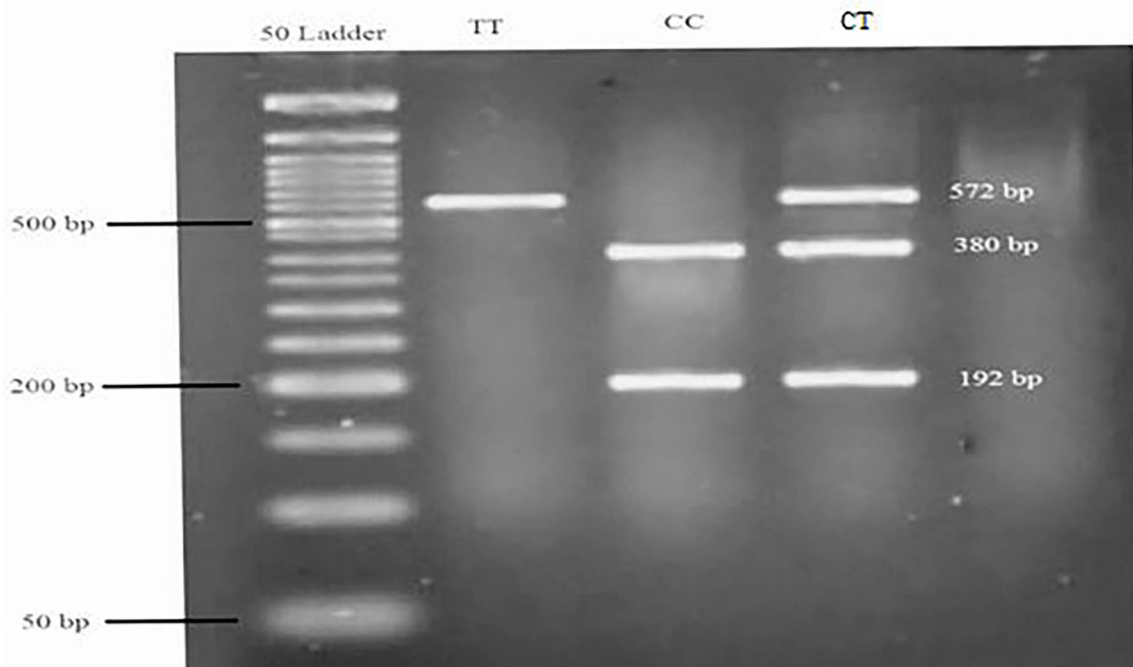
Genotyping of the FADS2 rs174583 variant by TaqI PCR-RFLP analysis. A 50-bp ladder was used to determine the length of the digested products. TT = homozygous mutated (572 bp), CC = homozygous wild-type (380 and 192 bp), CT = heterozygous mutated (572, 380, and 192 bp).
